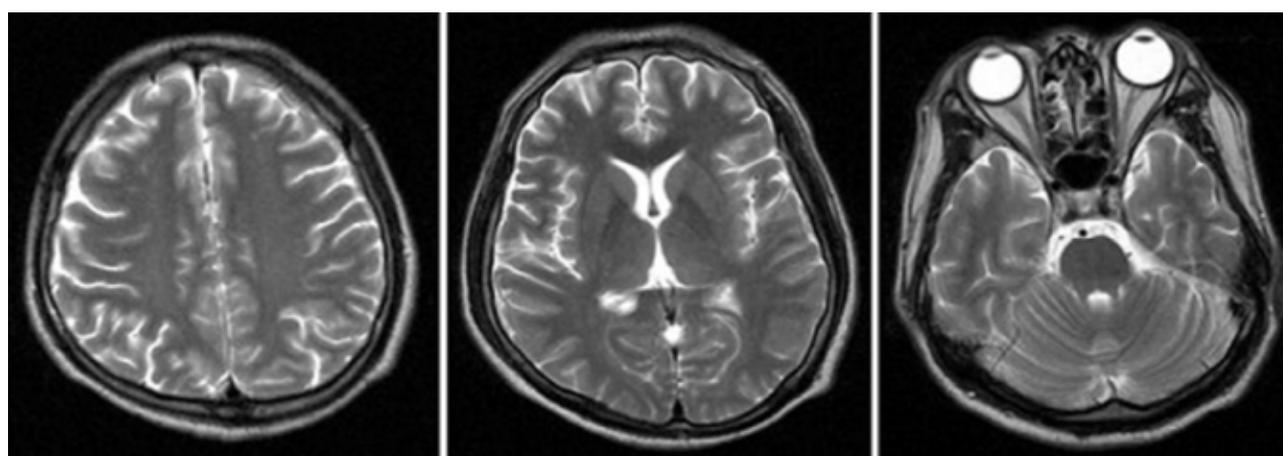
T<sub>2</sub>-weighted MRI showing mild diffuse cerebral atrophy.
